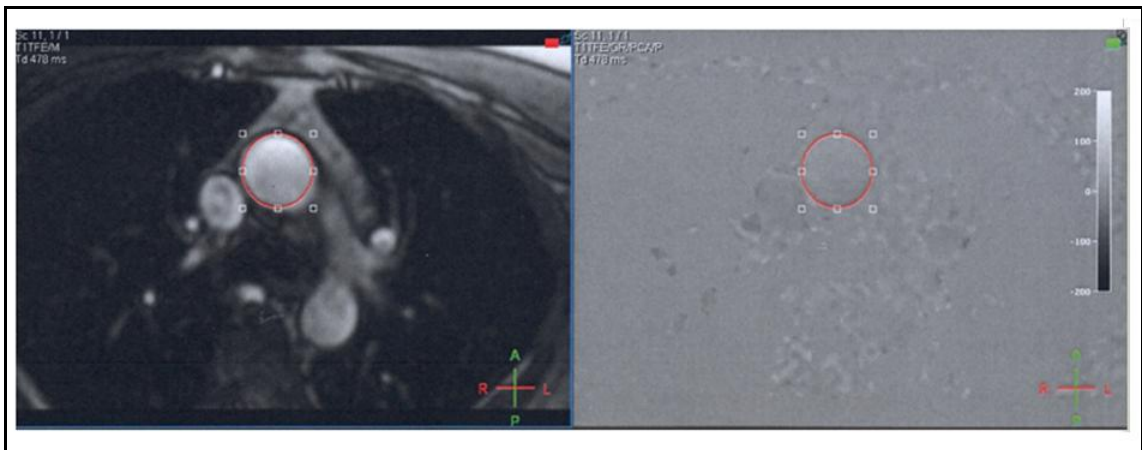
2D MRI data, magnitude & phase
